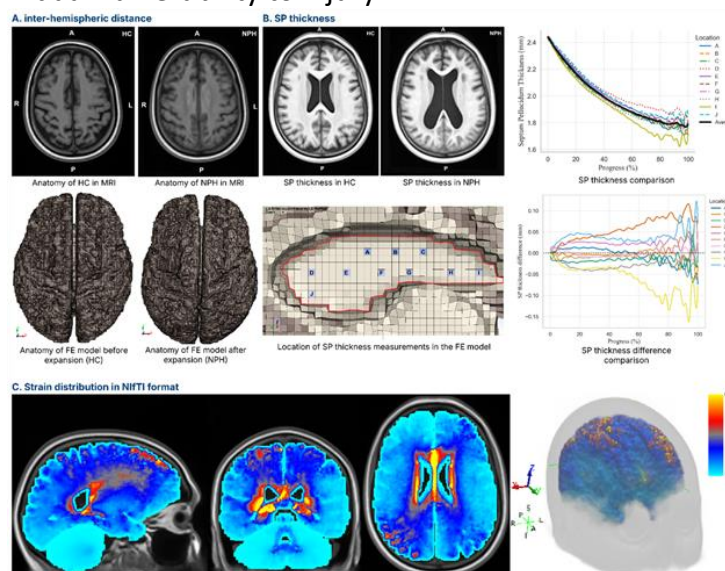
(A–B) MRI and model predict reduced inter-hemispheric distance and SP thickness. (C) Strain concentrates near ventricles in NPH.
